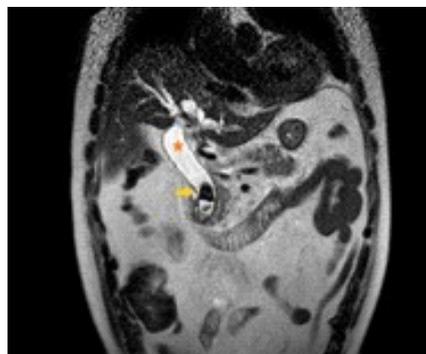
Coronal T2W MRI shows that common bile duct is dilated with mild intrahepatic duct dilatation (Asterisk). Filling defect within the distal common bile duct keeping with choledocholithiasis (Arrow)
